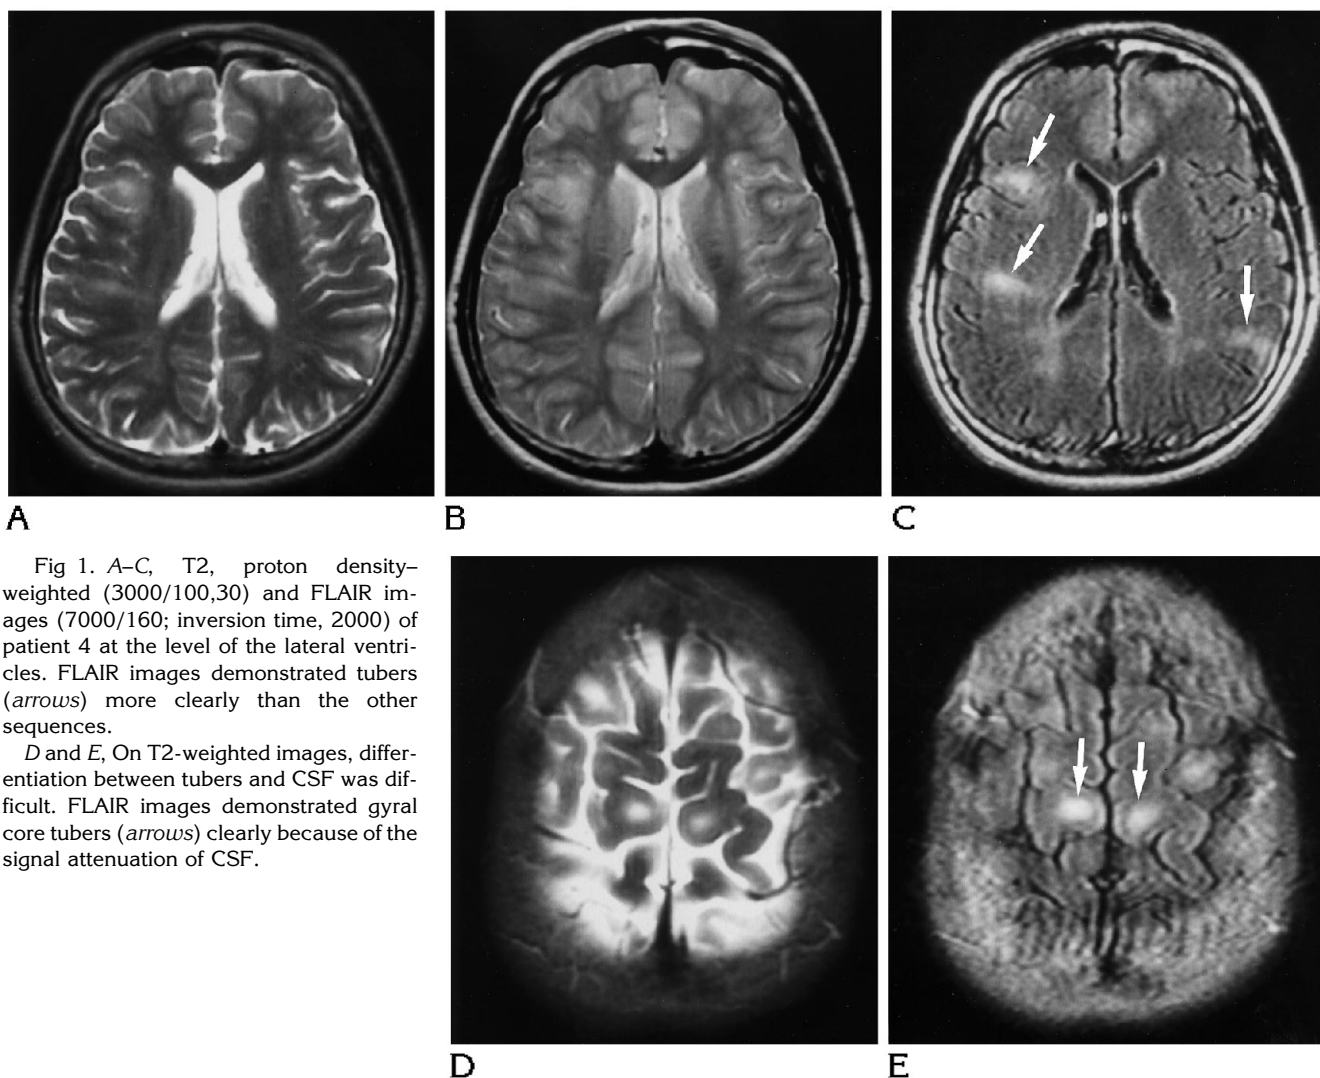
A-C, T2, proton density-weighted (3000/100,30) and FLAIR images (7000/160; inversion time, 2000) of patient 4 at the level of the lateral ventricles. FLAIR images demonstrated tubers (arrows) more clearly than the other sequences.
